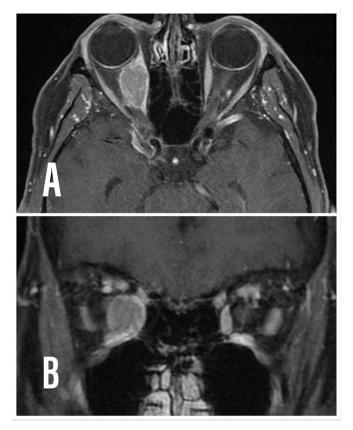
Axial (A) and coronal (B) T1-weighted fat-saturated MRI with gadolinium demonstrating a right isointense medial rectus muscle mass.
